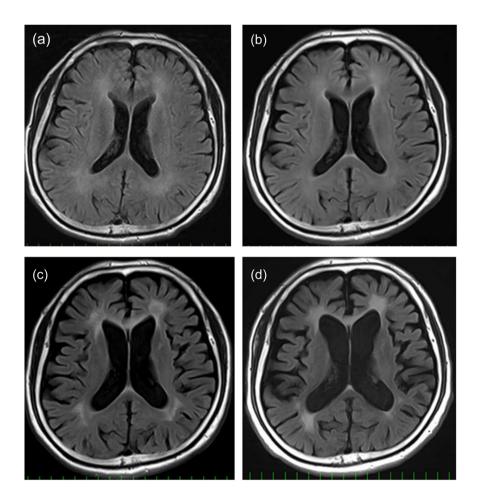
Brain magnetic resonance images in an axial section at the body of the lateral ventricle using a fluid attenuated inversion recovery sequence: (a) at the 13th hyperbaric oxygen (HBO) therapy session, (b) at the 72nd HBO therapy session, (c) 2 years after HBO therapy, and (d) 8 years after HBO therapy.
